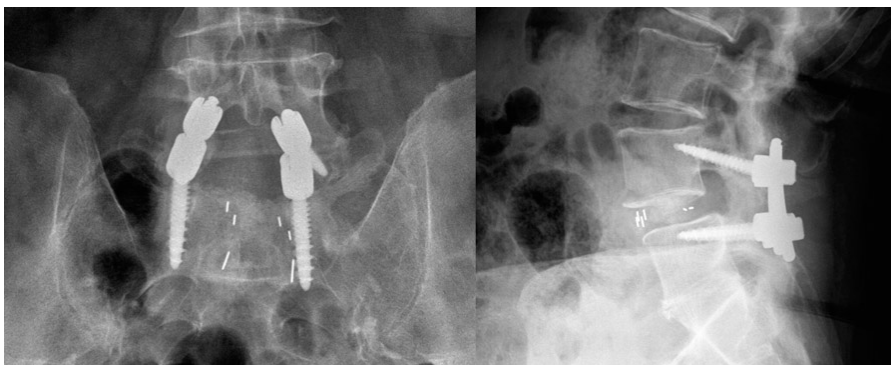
AP and lateral x-rays showing trajectory of CBT screws.
